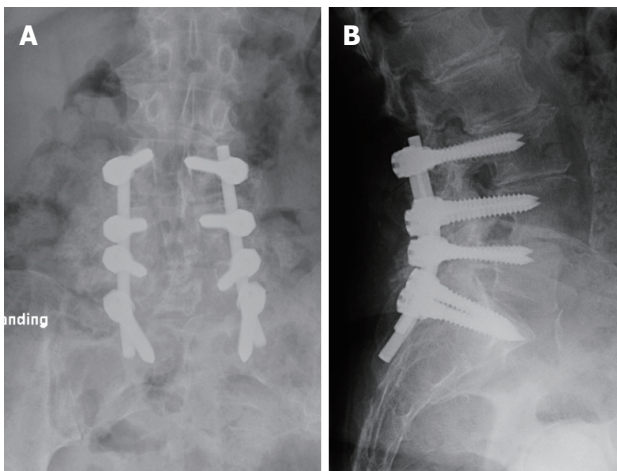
Postoperative anteroposterior and lateral roentgenograms showed L3-S1 instrumentation and posterolateral fusion.
